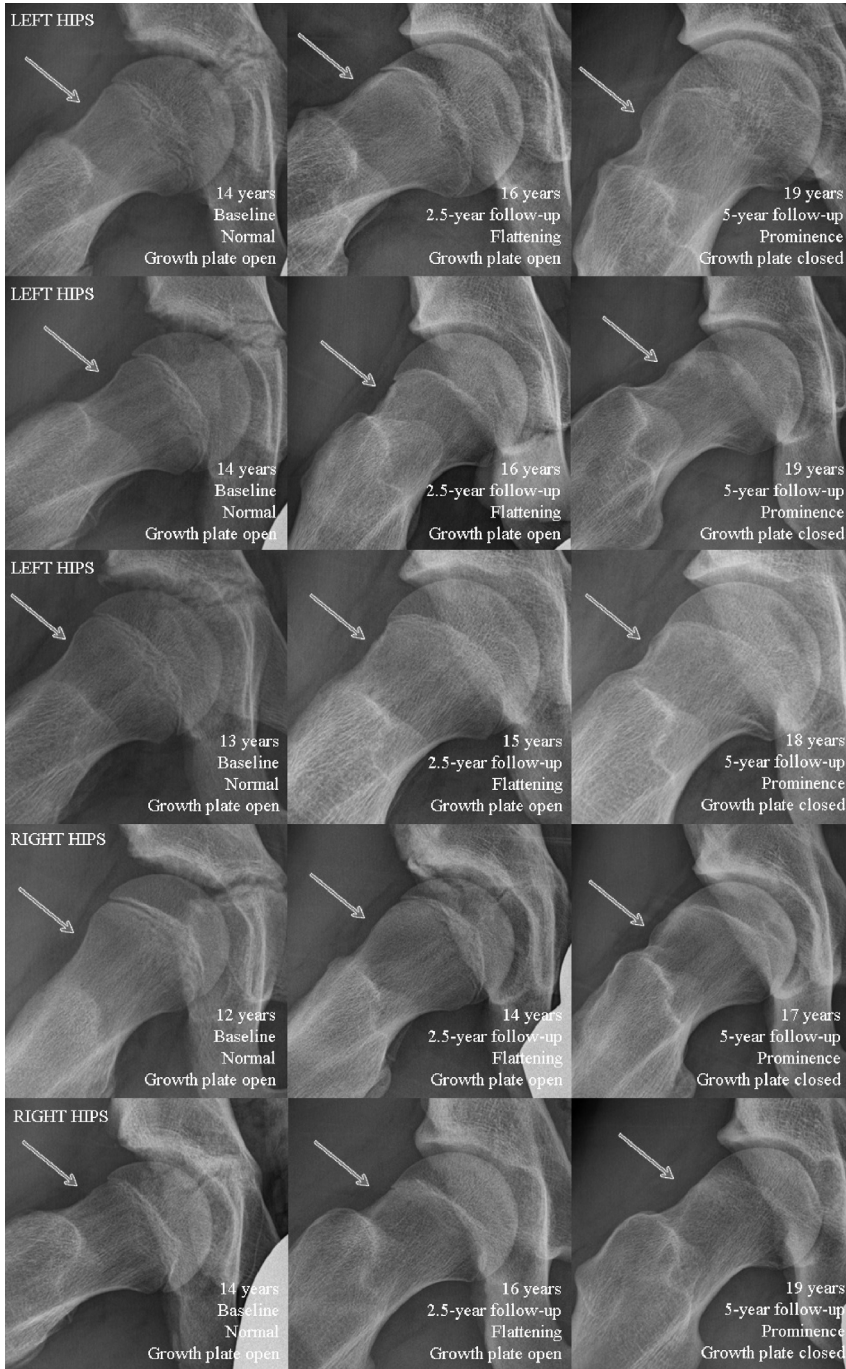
Cam morphology development based on visual scores during follow-up in five different hips of five persons on frog-leg lateral radiographs. Note: In all presented hips, cam morphology development based on visual score from baseline to 2.5-year follow-up, and from 2.5-year follow-up to 5-year follow-up, is observed.
